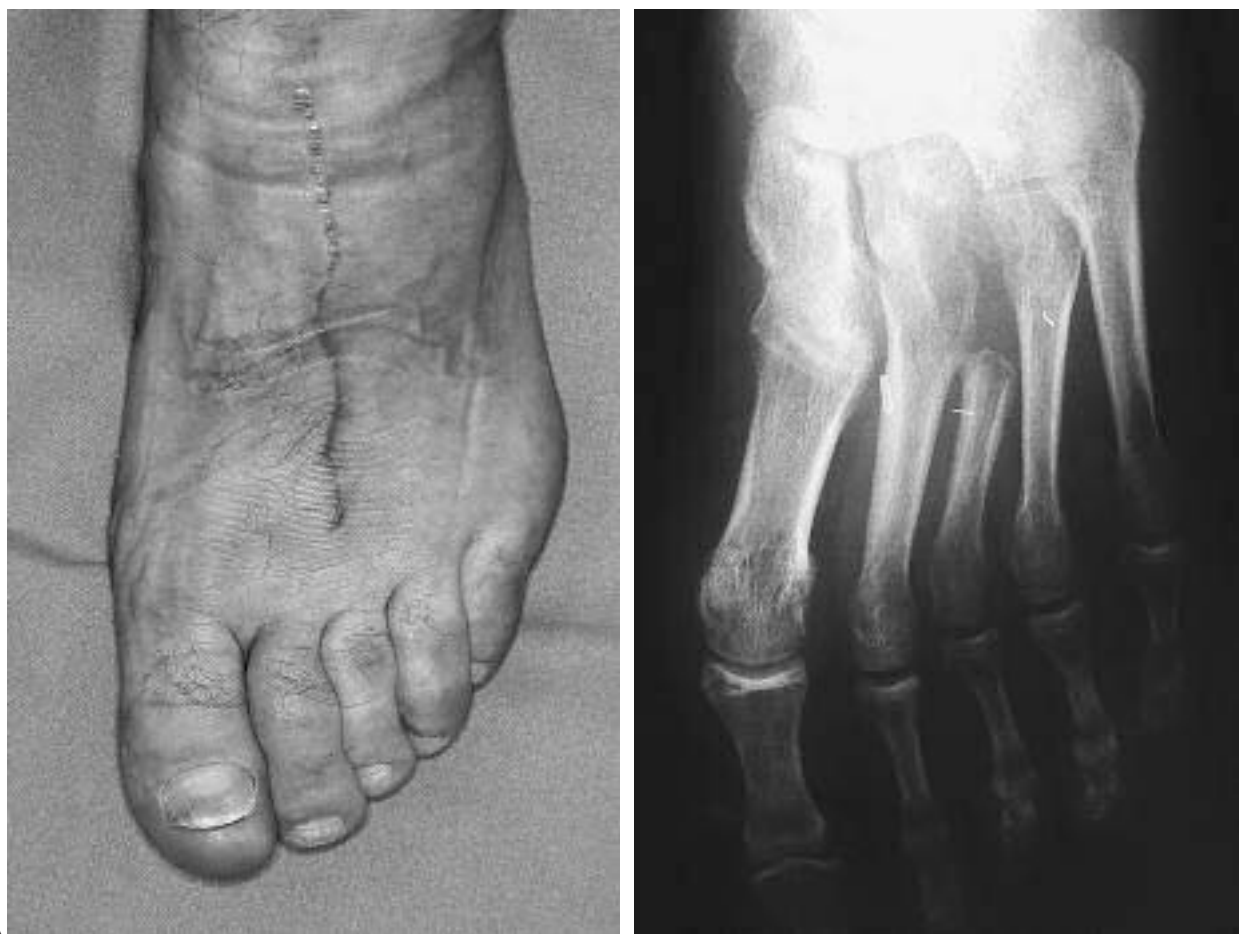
(A) Donor site of case N°2 patient. (B) X-ray showing excision of 3rd metatarsal.
